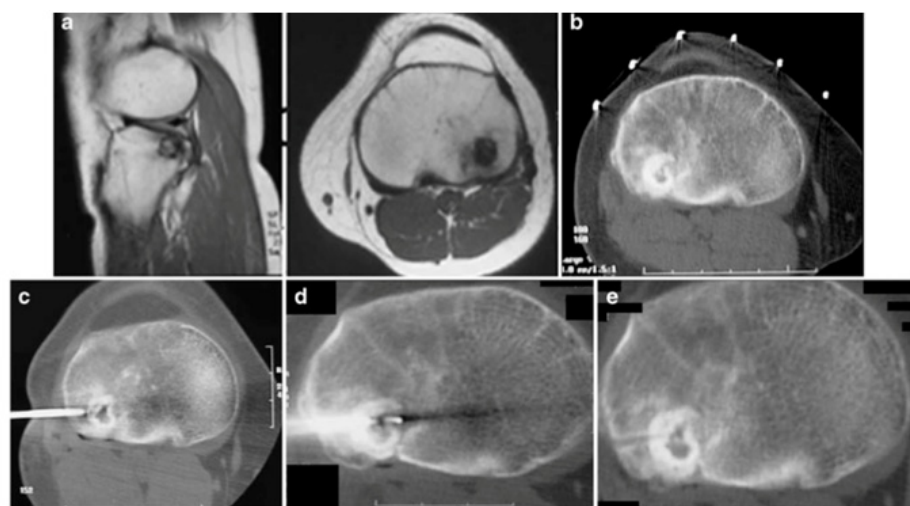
RFA of osteoid osteoma in a 14-year-old girl. a MR images shows a small, well-defined lesion in the proximal tibial epiphysis. b CT during percutaneous RF ablation shows a radiolucent nidus with central calcification surrounded by a dense rim of sclerosis. Note markers for planning the skin entry point. c CT shows the bone biopsy probe tip at the margin of the nidus. d CT shows the tip of the RF electrode within the nidus after slight withdrawal of the penetrating cannula. e Control image obtained immediately after the intervention shows the biopsy tract with no bleeding(12)
